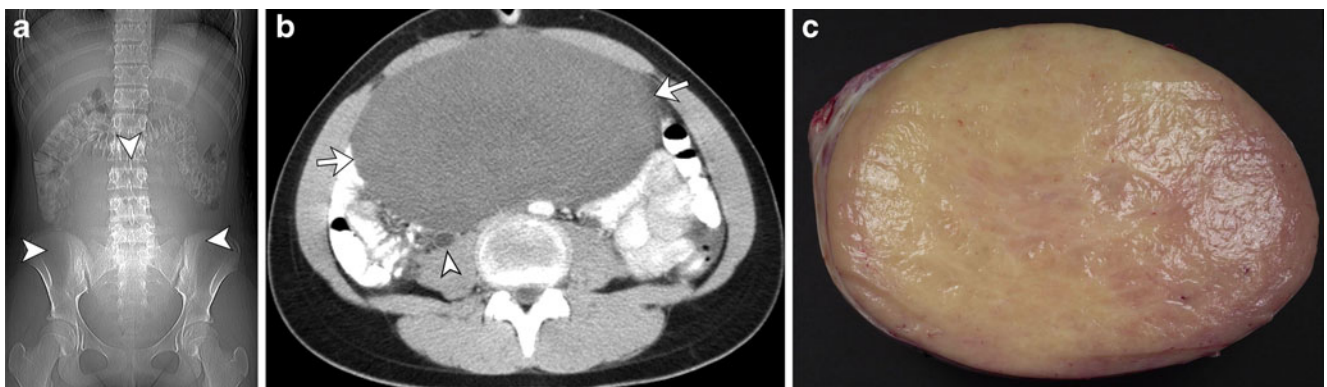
Fibrothecoma in a 13-year-old girl who presented to the emergency department with abdominal fullness and pain. a Scout view of the abdomen shows a mass (*arrowheads*) displacing the bowel loops. b Axial enhanced CT of the abdomen demonstrates a relatively homogeneous mass (*arrows*) with mild enhancement. Note the right
